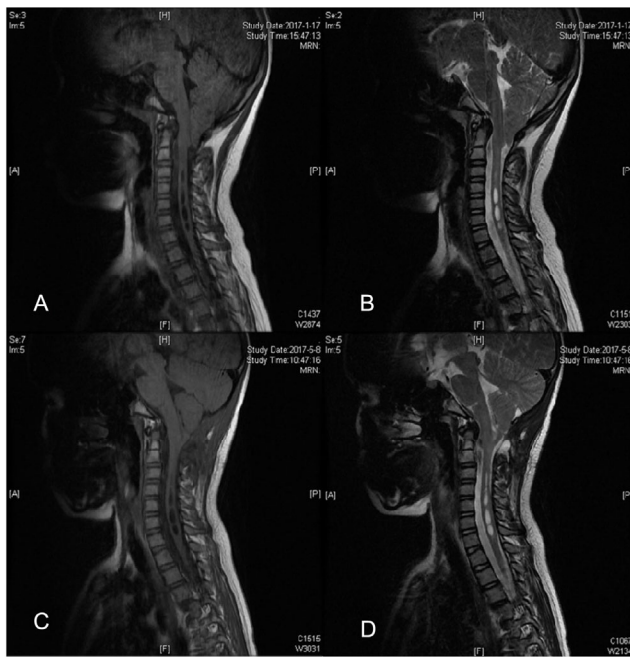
The MRI of Chiari malformation type I shows that the volume of posterior cranial fossa is significantly larger than that of hindbrain, and ODA was an acute angle.
